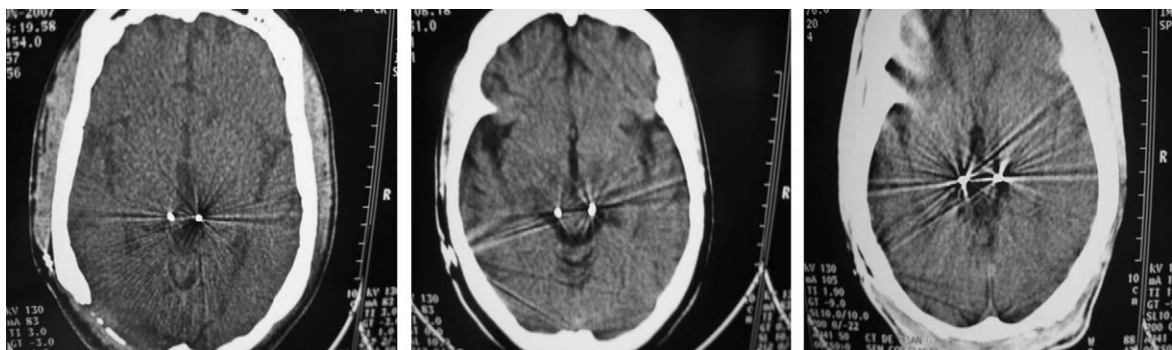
Axial CT slices at the level of the posterior commissure showing the electrodes' tip (seen as white dots) position in three different patients.
